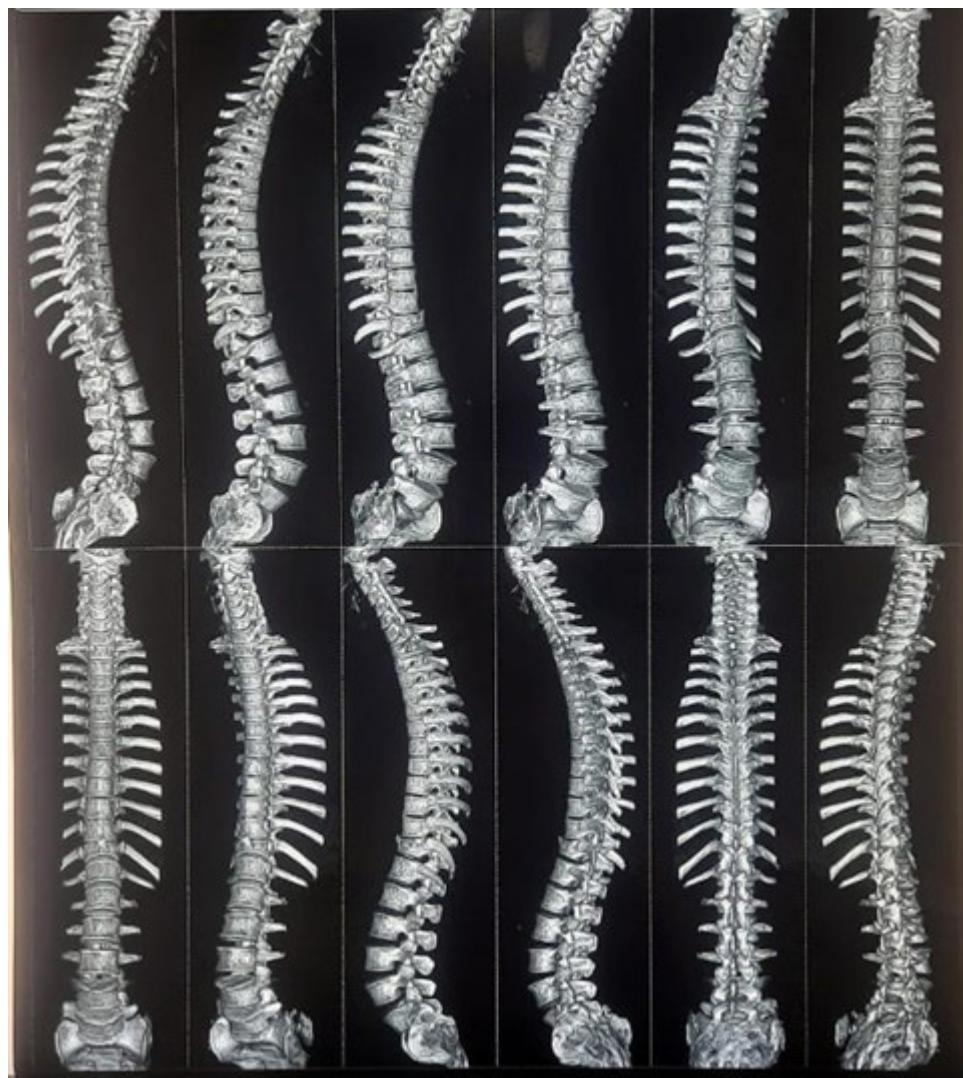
Computed tomography imaging shows D11 vertebra fracture.
